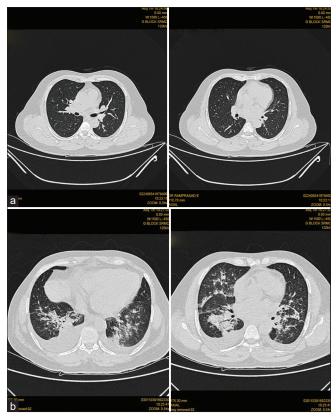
(a) CT scan of the chest prior to kidney transplantation: normal lung fields. (b) CT scan of the chest on day 3 post-transplantation- bilateral mild pleural effusion and homogenous opacites in bilateral lung fields
